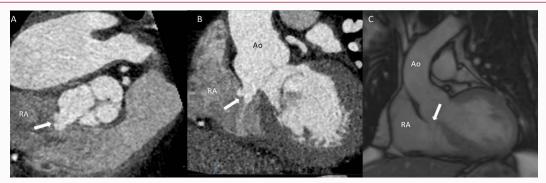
Panel A and B. Computed tomography. Aorta to Right Atrial (RA) fistula (arrow). Panel C: Cardiac Magnetic Resonance Imaging. Aorta to RA fistula (arrow).
